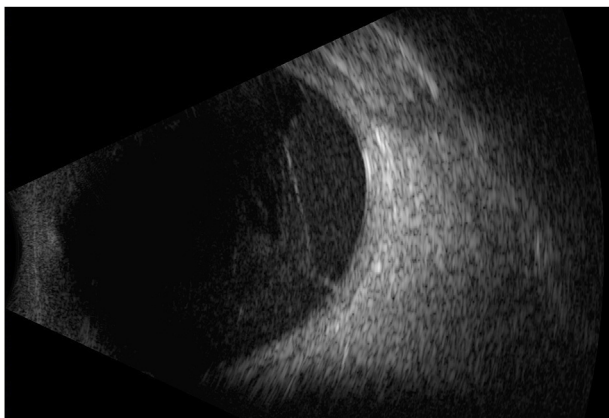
Vitreous opacification consistent with a dense inflammatory reaction seen on B-scan ultrasound (POD 5). POD 5 = postoperative day 5.
